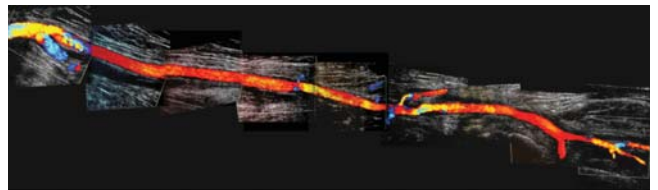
Colour Doppler picture of the same anatomical section.
